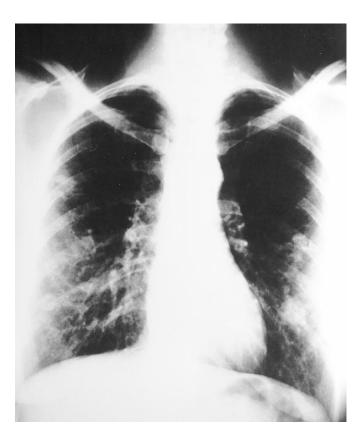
Plain chest radiograph showing multiple PAVM in the lower and middle zones of both lungs from a 22-yr-old woman with severe dyspnea and hypoxemia.
